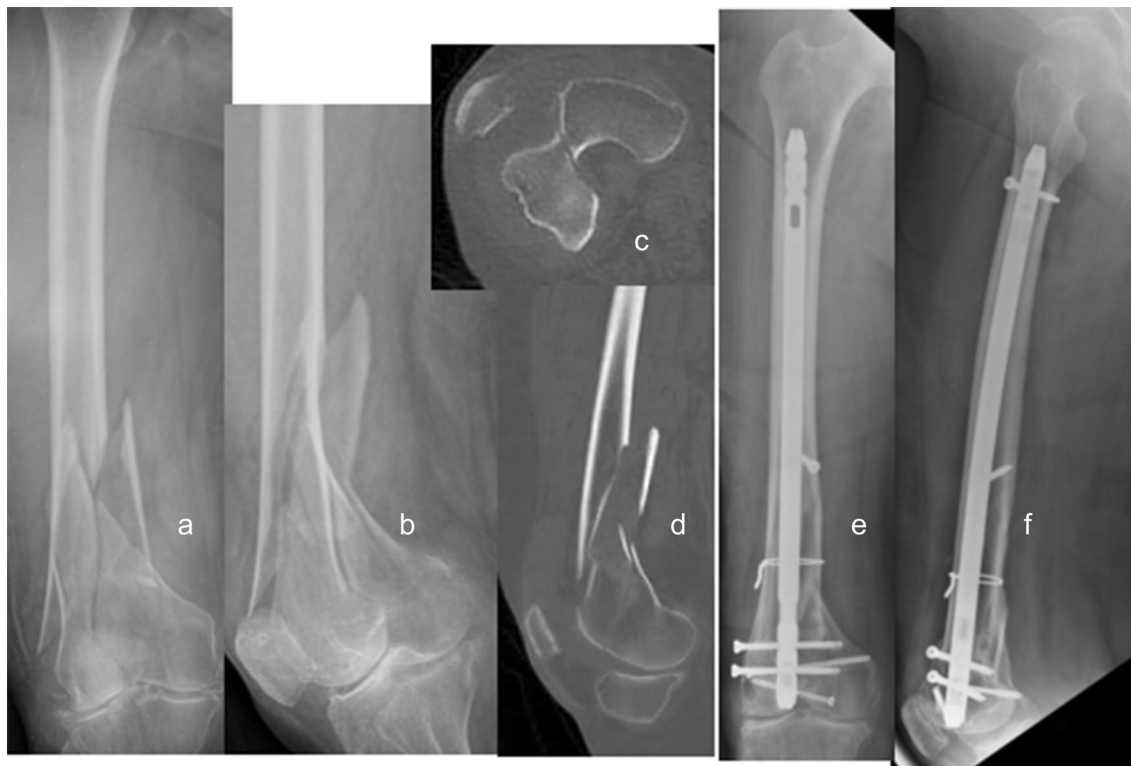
a–d AP and Lat X-ray and CT scan showing comminuted distal femur fracture with articular involvement and osteoarthritis of the knee (no previous pain reported) in an 80-year-old woman. e–f AP
